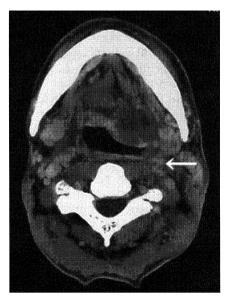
(Case 1, 58-year-old man) CT shows an internal carotid artery injury made by tumor invasion.
